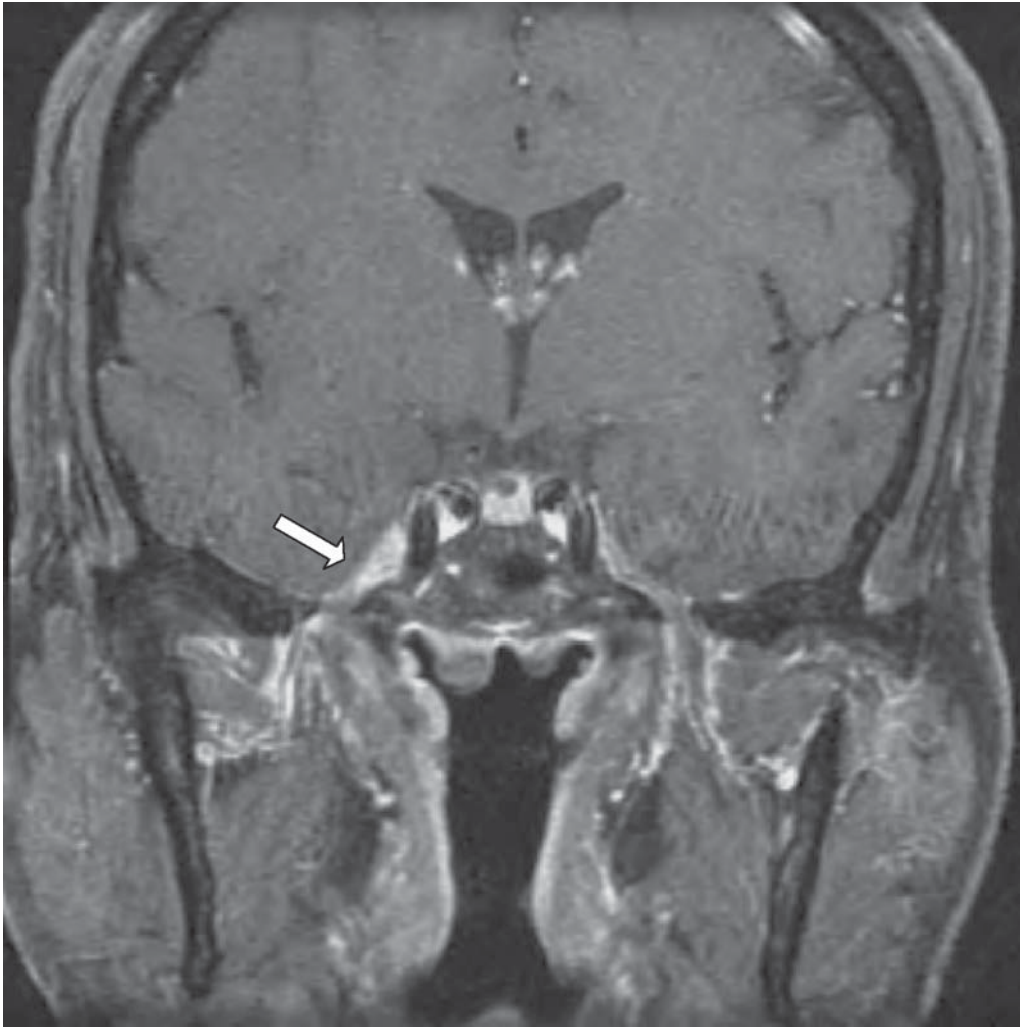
A 68-yr-old man presented with retro-orbital pain, ipsilateral decreasing vision, neuralgic pain and paresthesias in the distribution of the supraorbital nerve, and then double vision. MRI suggested an invasive meningioma. Biopsy confirmed NHL.
